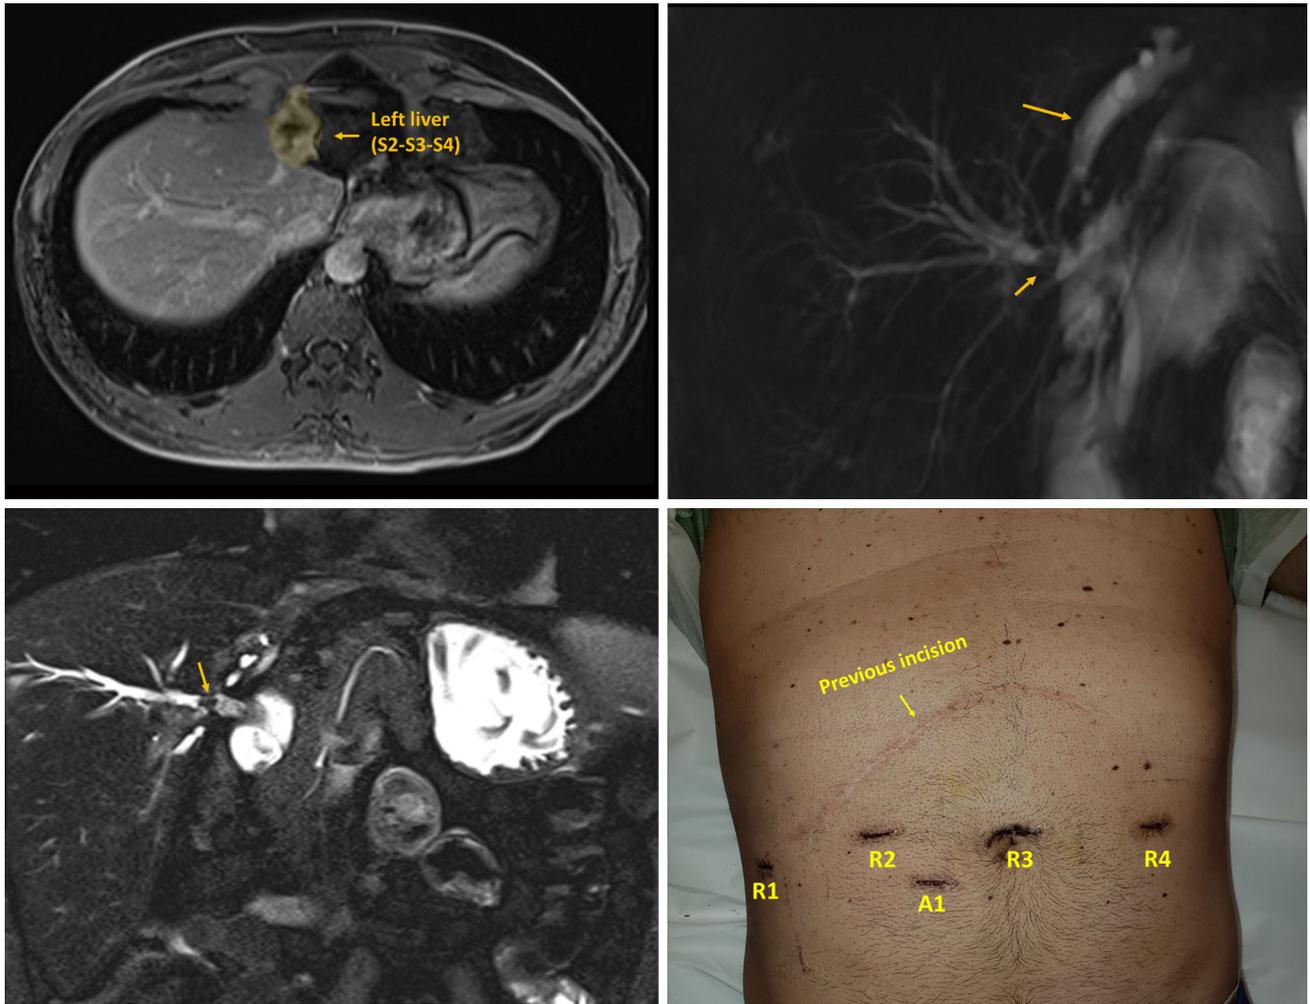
Bile duct injury after cholecystectomy. a Magnetic resonance imaging (MRI, axial view) showing complete atrophy of the left hemiliver (segments 2–4). b MRI cholangiogram showing important dilation of the left bile duct (*large arrow*) and areas of stenosis/stones in the right duct (*small arrow*). c MRI (coronal view) showing
